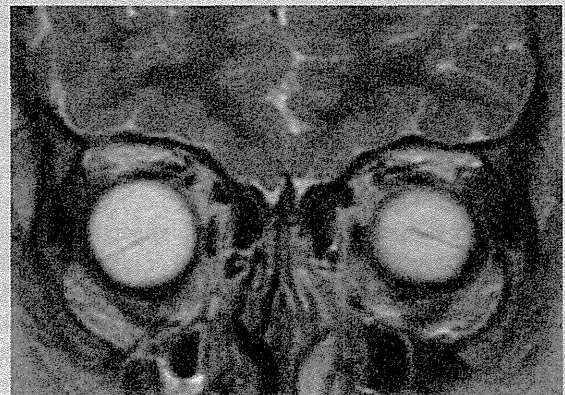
MR coronal image, T2-weighted. Magnetic resonance imaging also showed fibrous intraocular tissue in the eye. [Color figure can be seen in the online version of this article, available at [http://onlinelibrary.wiley.com/journal/10.1002/\[ISSN\]1552-4833](http://onlinelibrary.wiley.com/journal/10.1002/[ISSN]1552-4833)]
